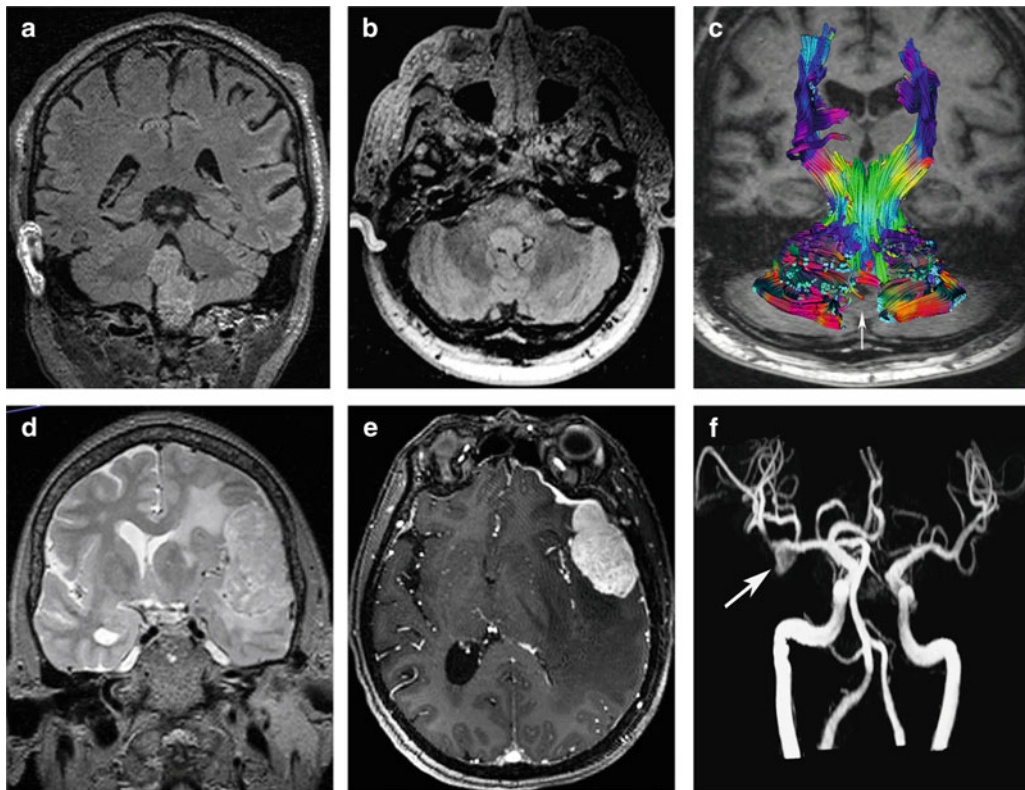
Imaging quality at 3.0 T: ioMRI images (a, coronal FLAIR; b, axial FLAIR) obtained from a patient with a 4th ventricle ependymoma. Post-resection images (c, DTI imposed on T1 images) with superimposed tractography demonstrate intact cerebellar white-matter anatomy following resection (arrow). Images of a sphenoid wing meningioma with dural tail (d, T2 coronal; e, T1 axial with gadolinium enhancement). MR-Angiography (f) demonstrates a small intra-cranial aneurysm (arrow)
